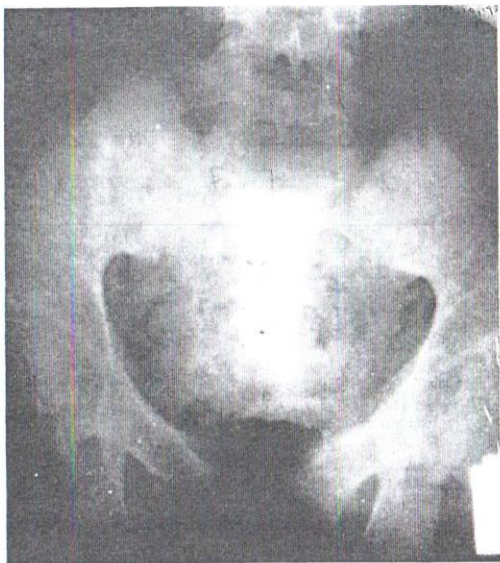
X-RAY SHOWING MARKED SEPARATION OF THE SYMPHYSIS PUBIS (1.5 CM.)
